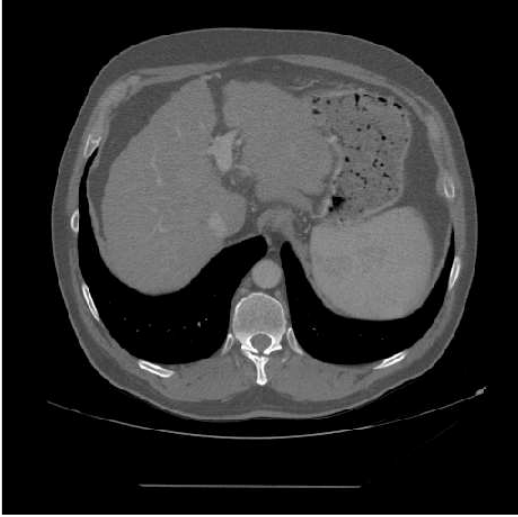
Transverse slice of a CT image I .
